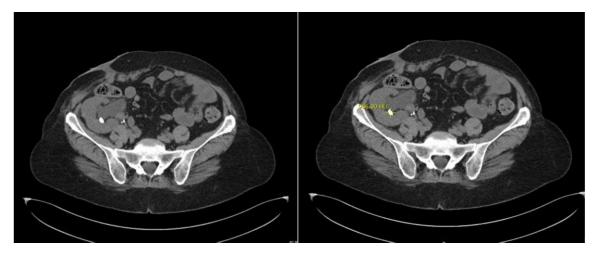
Follow-up CT scan: Renal lower calyx lithiasis (986 UH).
